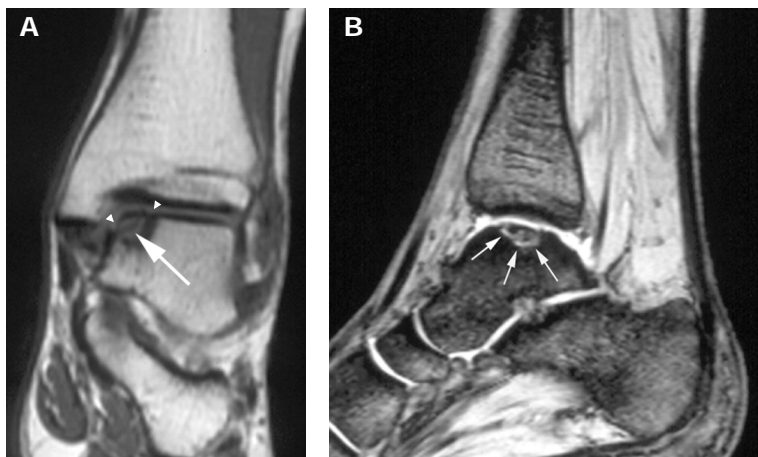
Male jumper with two years pain in the medial side of the ankle. A, Coronal T1-weighted SE demonstrates an osteochondral fragment in the medial aspect of the talar dome (white arrow). The talar cortex is fractured (arrowheads). B, Sagittal GRE MR image demonstrates an area of high-signal intensity around the osteochondral fragment typical of loosening (arrows).
